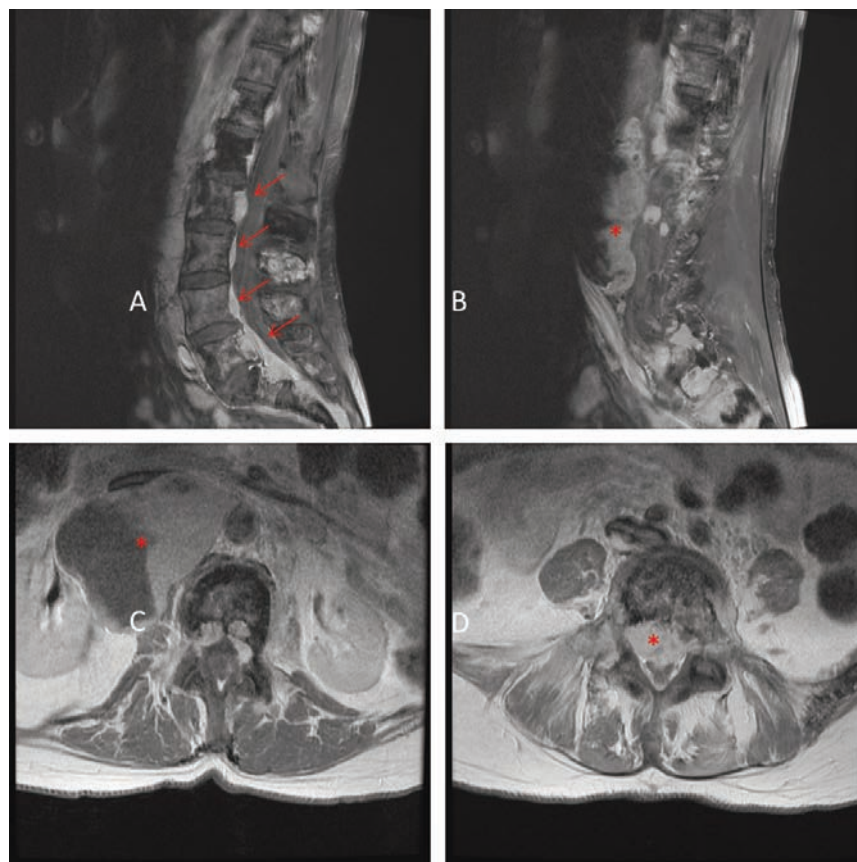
Lumbar spine magnetic resonance imaging (MRI). A,B) Sagittal T1-weighted MR image with contrast showing paraspinal enhancing soft tissue masses (arrows) and a large heterogeneous retroperitoneal mass extending from L1 through S1 (*). C) Axial T1-weighted MR image with contrast showing partially cystic and partially enhancing retroperitoneal mass measuring 6.0x6.8x11.9 cm3 (*). D) Severe narrowing of the spinal canal below the level of L5 (*).
